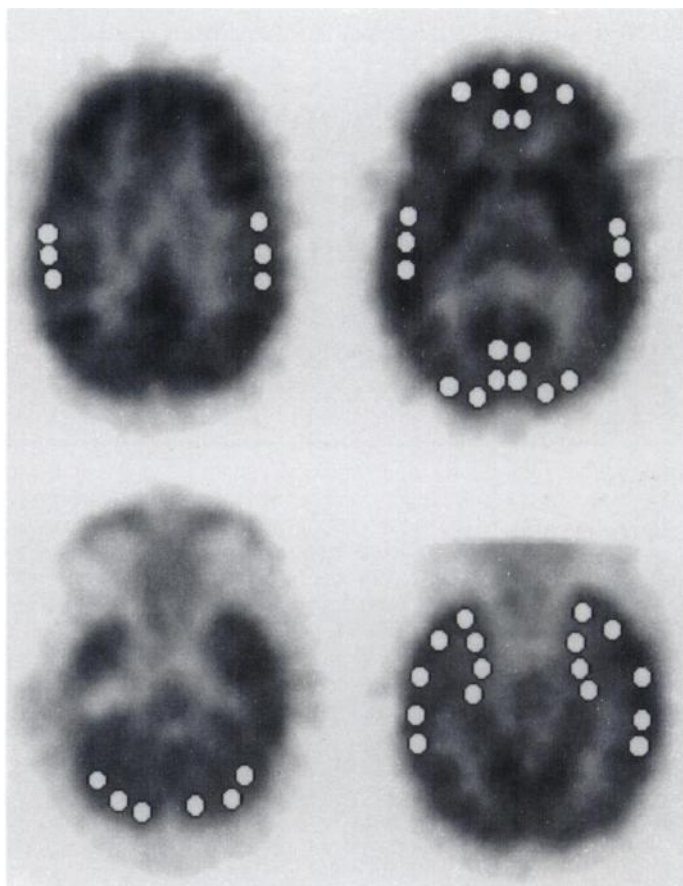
Template of ROI used to determine FDG uptake in selected brain regions. Top left: Axial view showing parietal ROI. Top right: Axial view showing frontal, opercular and occipital ROI. Bottom left: Axial view showing cerebellar ROI. Bottom right: View through the long axis of the temporal lobes showing mesial temporal lobe ROI, lateral temporal lobe ROI and temporal pole ROI. In addition to the frontal lobe ROI shown, three more ROIs (bilaterally) on a higher axial plane on each side were used. Each ROI was 4 mm in diameter.
